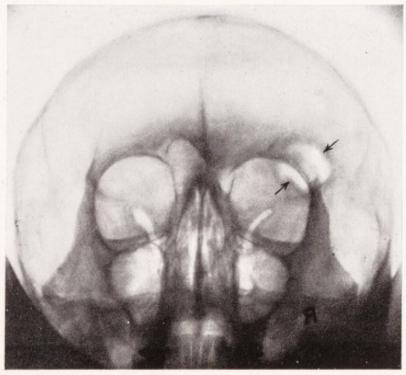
Case 7. Anteroposterior X-ray showing area of destruction in lateral wall of skull and roof of orbit.
